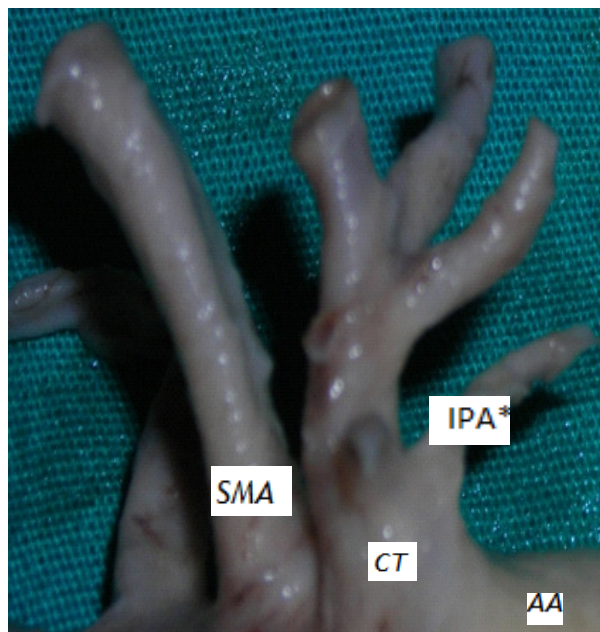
Inferior phrenic artery (IPA) arising as a single trunk from celiac trunk (CT).
